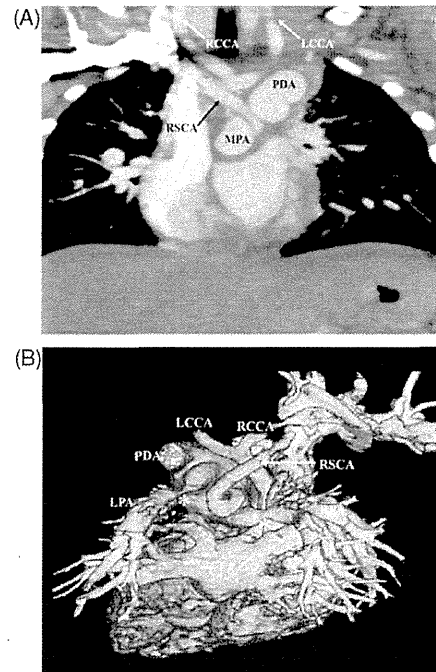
(A) Multidetector computed tomography angiogram showing the aberrant right subclavian artery (RSCA) from the main pulmonary artery (MPA). (B) Three-dimensional reconstructed image of the multidetector computed tomography clearly displayed the right subclavian artery (RSCA) arising from the main pulmonary artery, interrupted aortic arch, and the banding on both pulmonary arteries (asterisk). LCCA: left common carotid artery; LPA: left pulmonary artery; PDA: patent ductus arteriosus; RCCA: right common carotid artery; RPA: right pulmonary artery.
